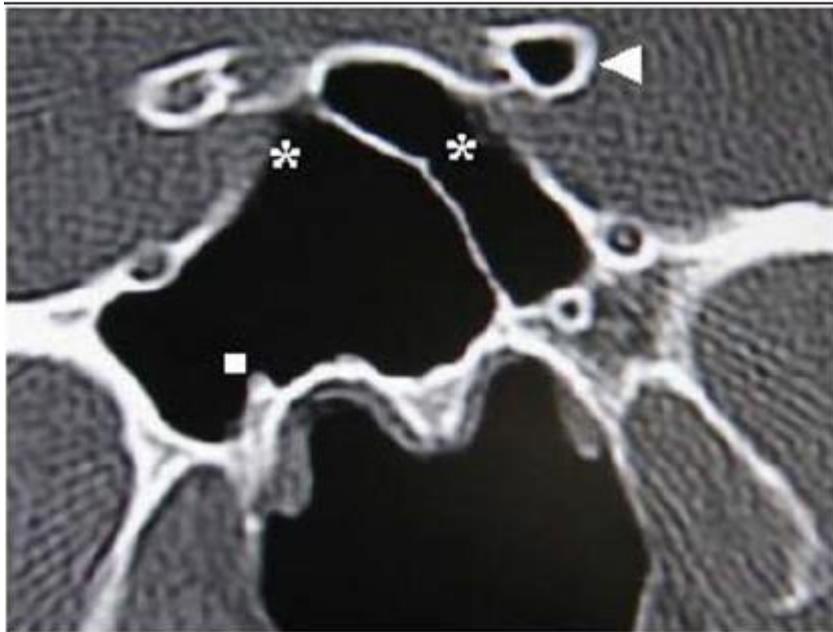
Coronal CT image showing dehiscence of internal carotid arteries (asterisks), pneumatization of left anterior clinoid process (arrowhead), and protrusion and dehiscence of right vidian canal (square)
